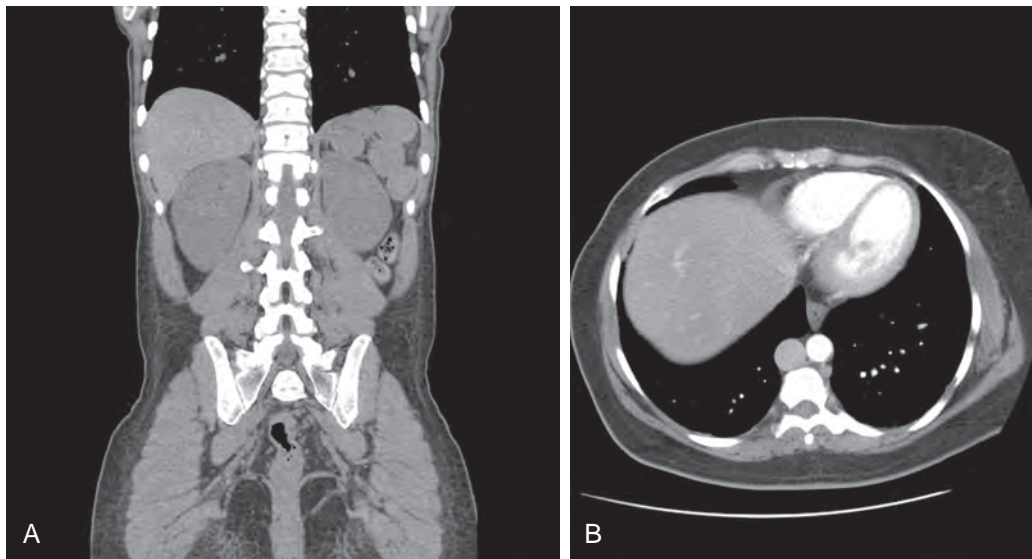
Polysplenia with azygos continuation of the inferior vena cava. A. Coronal CT scan demonstrating multiple spleens in the left upper quadrant. B. Axial CT scan demonstrates azygos continuation of the inferior vena cava in the same patient, a common finding in heterotaxy syndrome with polysplenia.
